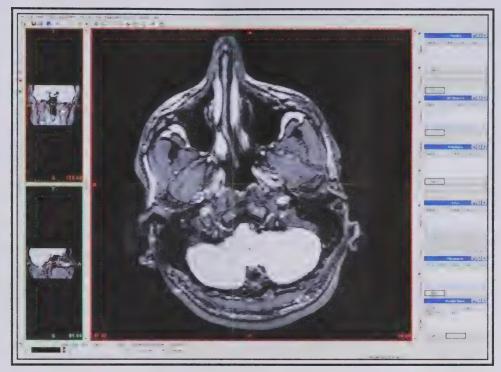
An MRI image displayed in Mimics®
